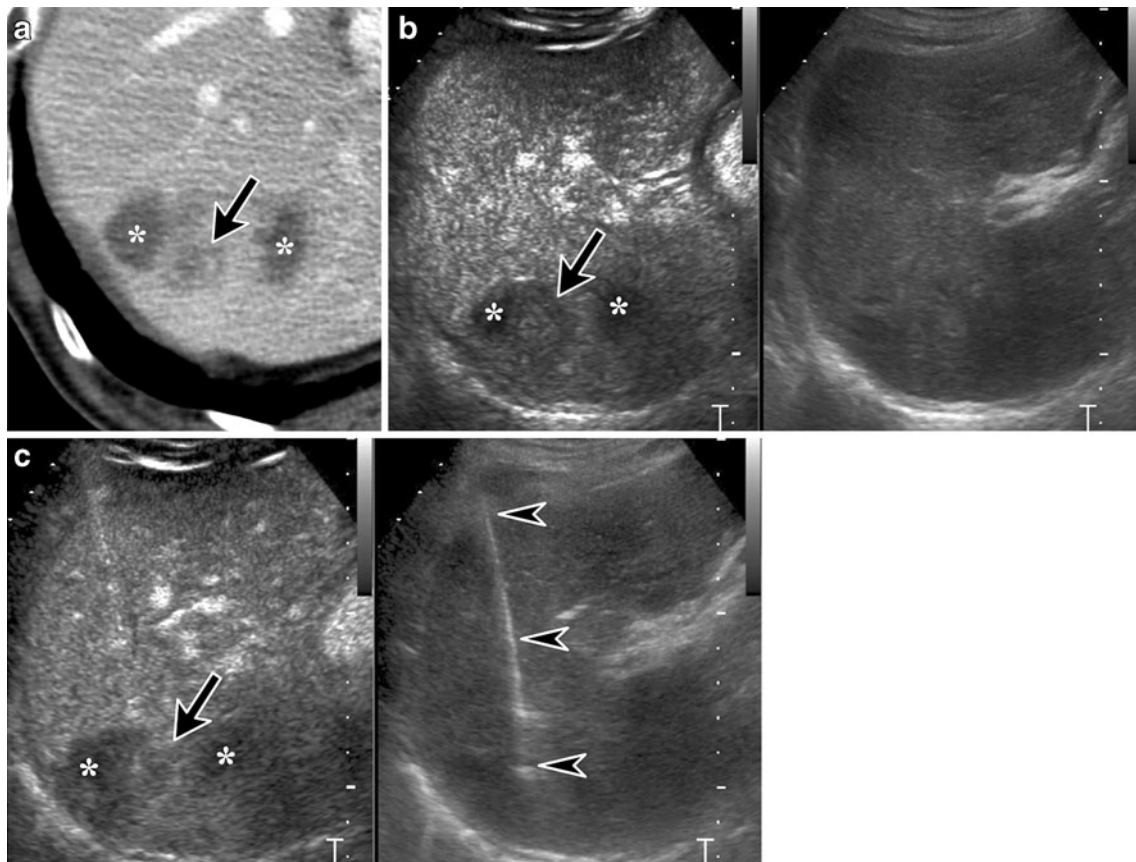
Marginal recurrence following radiofrequency ablation of hepatic metastases from gastric cancer in a 72-year-old man. a Contrast-enhanced transverse CT shows a suspicious viable tumour (*arrow*) around the two previously ablated areas (*asterisks*) at the segment 7. On B-mode ultrasound, the target lesion could not be confidently localised, as the target lesion and the surrounding previously ablated tumours appeared as a single conglomerate mass
